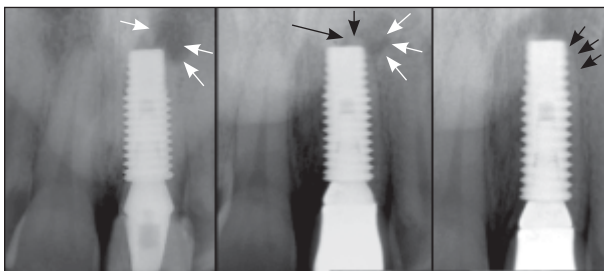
(left) Baseline periapical radiograph showing a periapical defect (white arrows). (center) The 24-month radiographic image revealed restriction of the size of the defect; the apex of the retained root portion is delineated (black arrows). (right) At 36 months, there were no signs of radiolucency, consistent with defect fill. Resorption of the apex of the root was noted.
